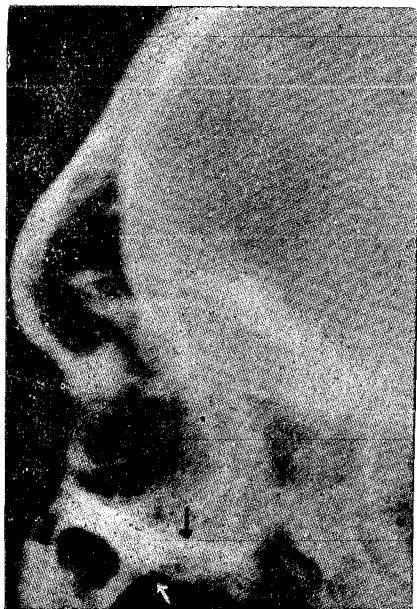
Lateral view of the floor of Orbit (X-ray) white arrow points to the fractured ramments of orbital floor. Black arrow points to the shadow cast by the plate of Stent Campo.
